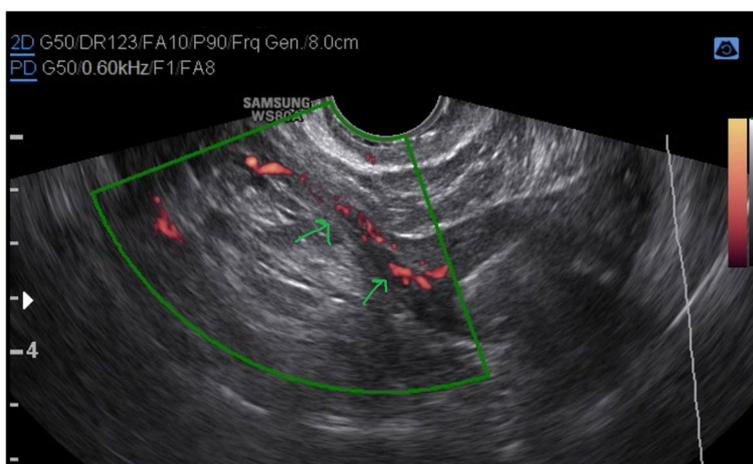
Power Doppler showing the patent left fallopian tube with foam flow
